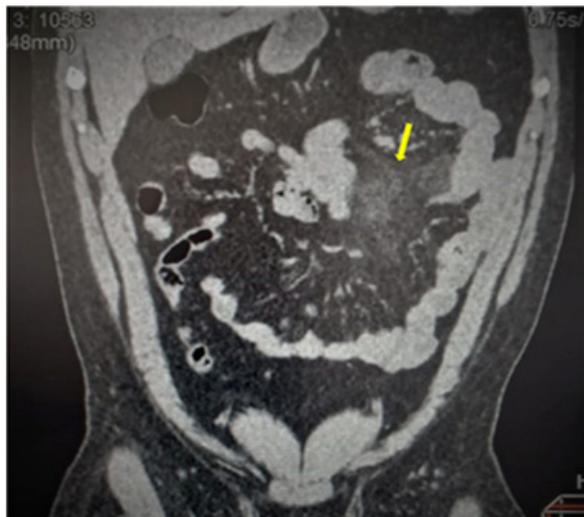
Abdominal CT scan with contrast injection in coronal section showing a localized area of mesenteric fatty over density, without individualizable tissue mass (misty mesentery).
